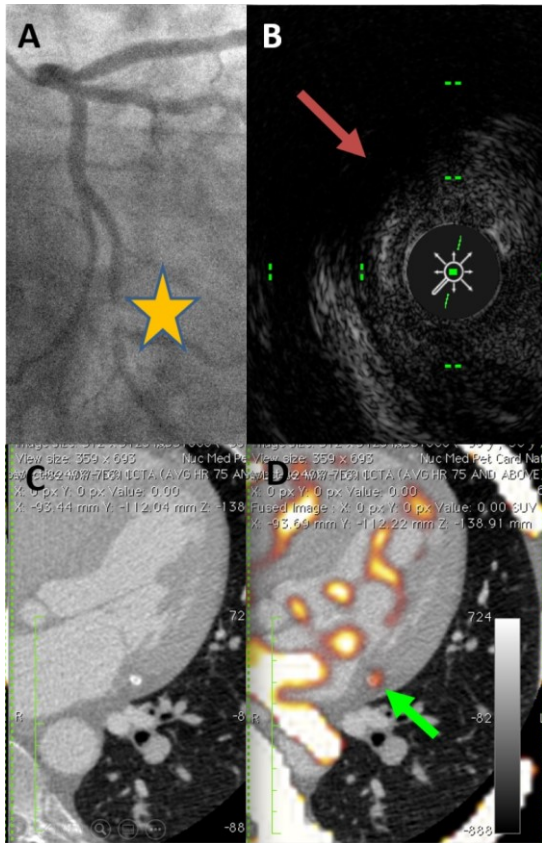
Panel of images demonstrate a ^{18}F -NaF acquired at Cedars-Sinai Heart Institute. Panel A shows the patient's distal circumflex lesion (yellow star) with corresponding 60 MHz IVUS image (Panel B) showing lipid-rich plaque with ultrasound attenuation from 9 to 12 o'clock (red arrow). Panels C and D show a non-fused and fused CCTA, respectively. Panel D shows NaF uptake in the distal portion of the left circumflex corresponding to the patient's area of acute infarction and presentation with acute coronary syndrome (green arrow).
